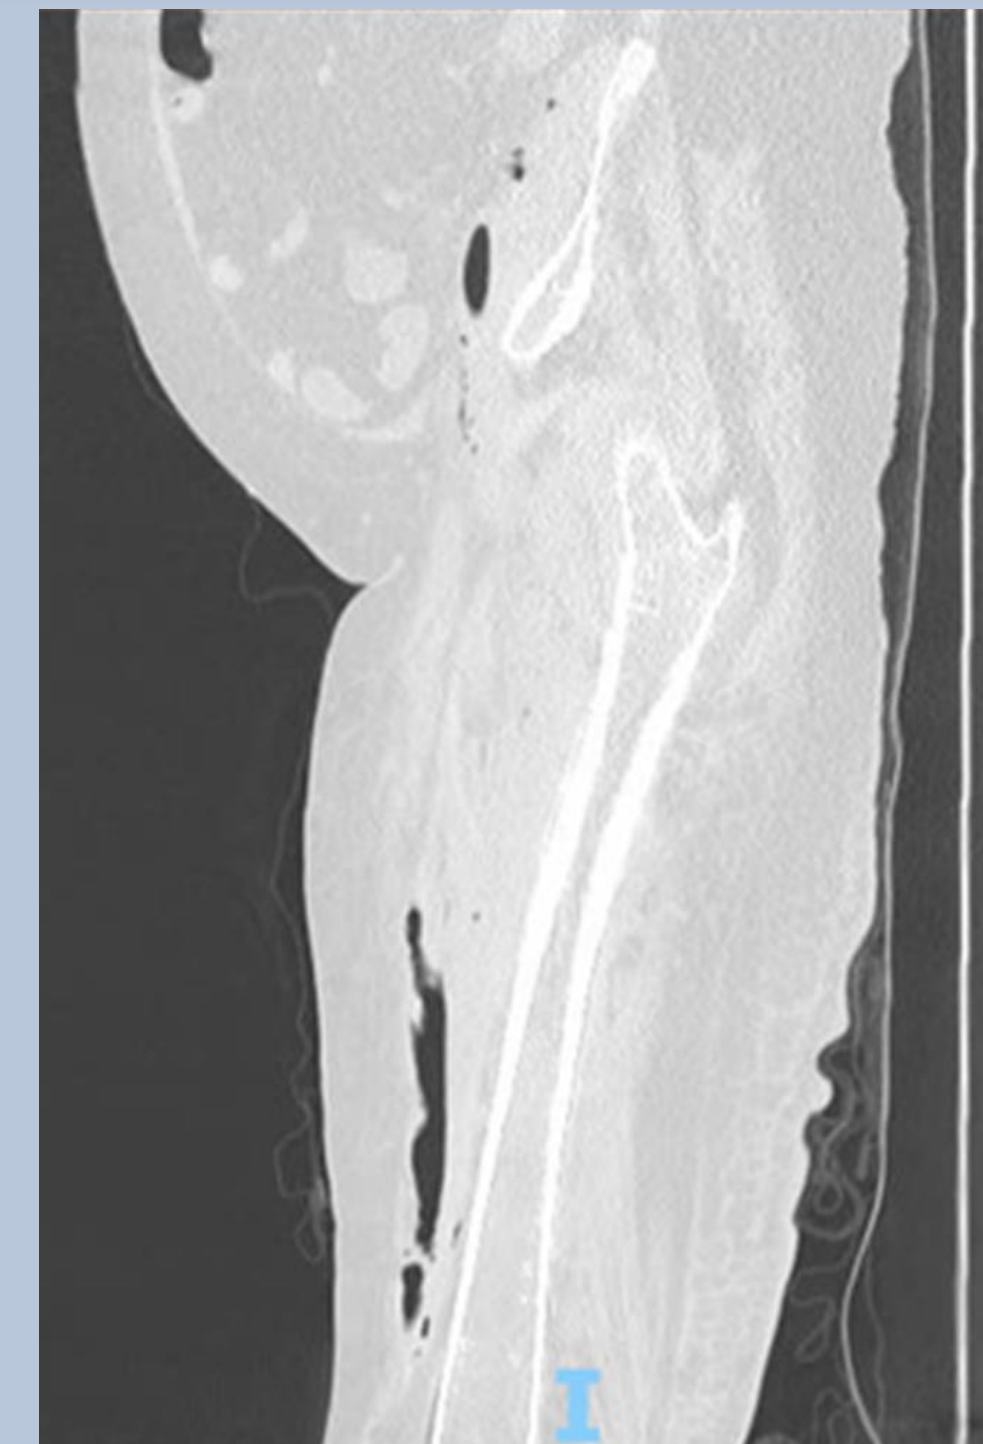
CT demonstrating gas tracking from the retroperitoneum to the right leg.
